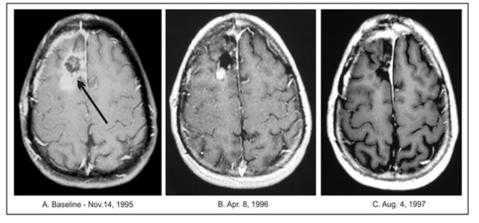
Axial MRI images [41]: A) Baseline MRI showing residual GBM in the right frontal lobe (arrow) following subtotal resection of GBM; B) Follow-up MRI showing an 88% reduction in the size of the residual frontal lobe GBM, confirming a PR; C) Post therapy MRI showing no residual GBM following total resection of remaining tumor.
